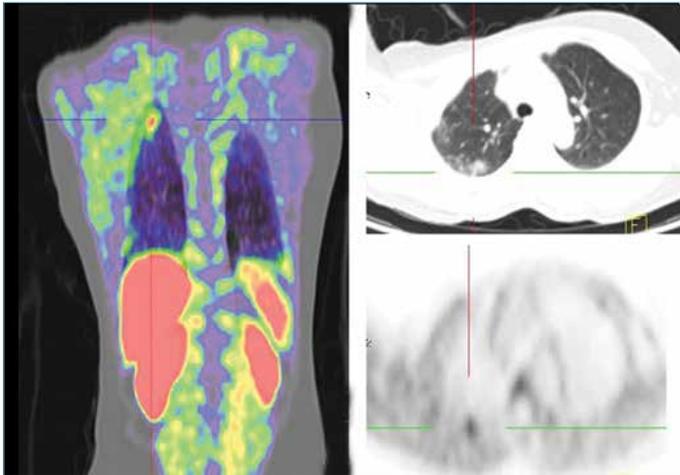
Fused ^{18}F -Flurocholine PET-CT (left), axial CT (right upper), and FCH-PET (right lower), showing the FCH uptake of the metastatic breast lesion in the right lung apex
